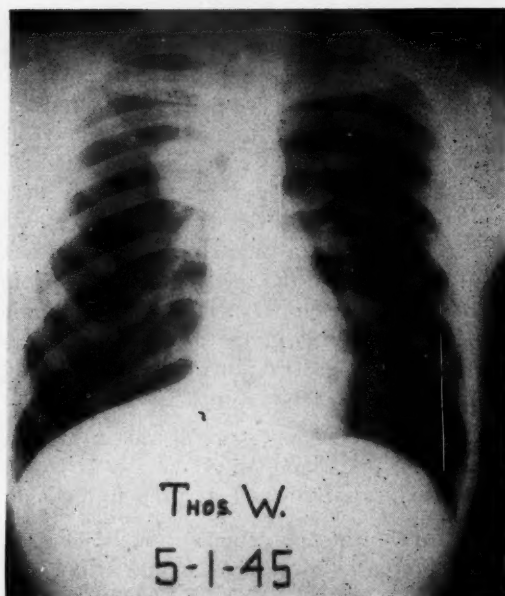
Roentgenogram of chest showing circumscribed opacity in right upper lobe. Bronchogenic cyst arising from right upper lobe bronchus.
